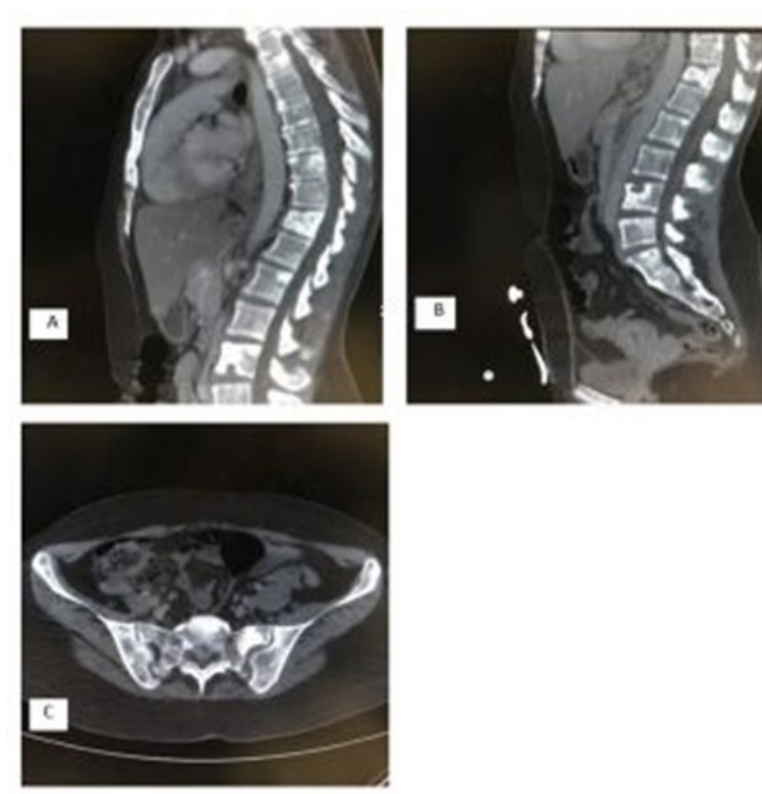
Other selected images from the same patient. Sagittal reformatted images from a CT scan of the spine and axial image of the pelvis reveal diffuse osteosclerotic lesions representing bony metastasis (A, B, and C).
